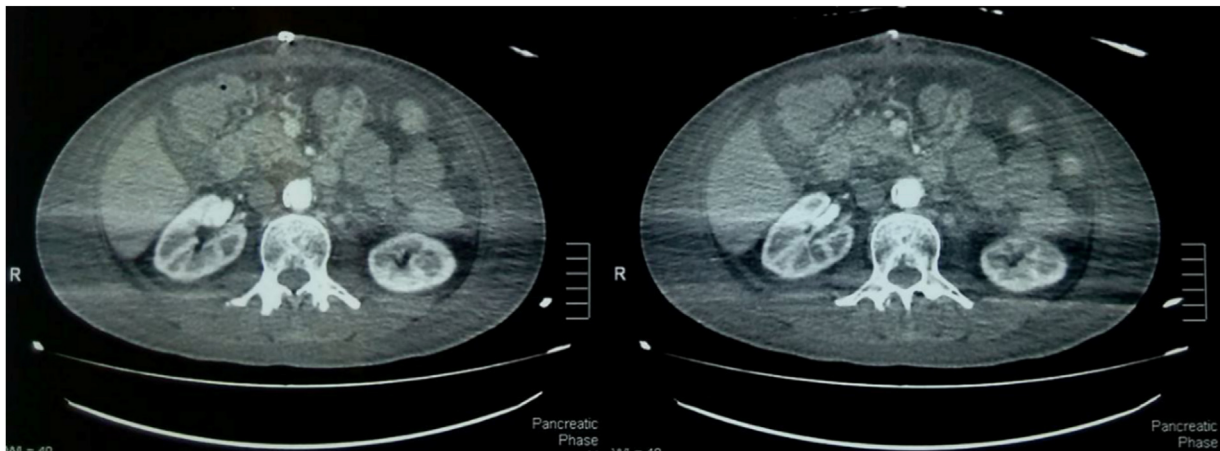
CTA where no pseudoaneurysm is identified.
